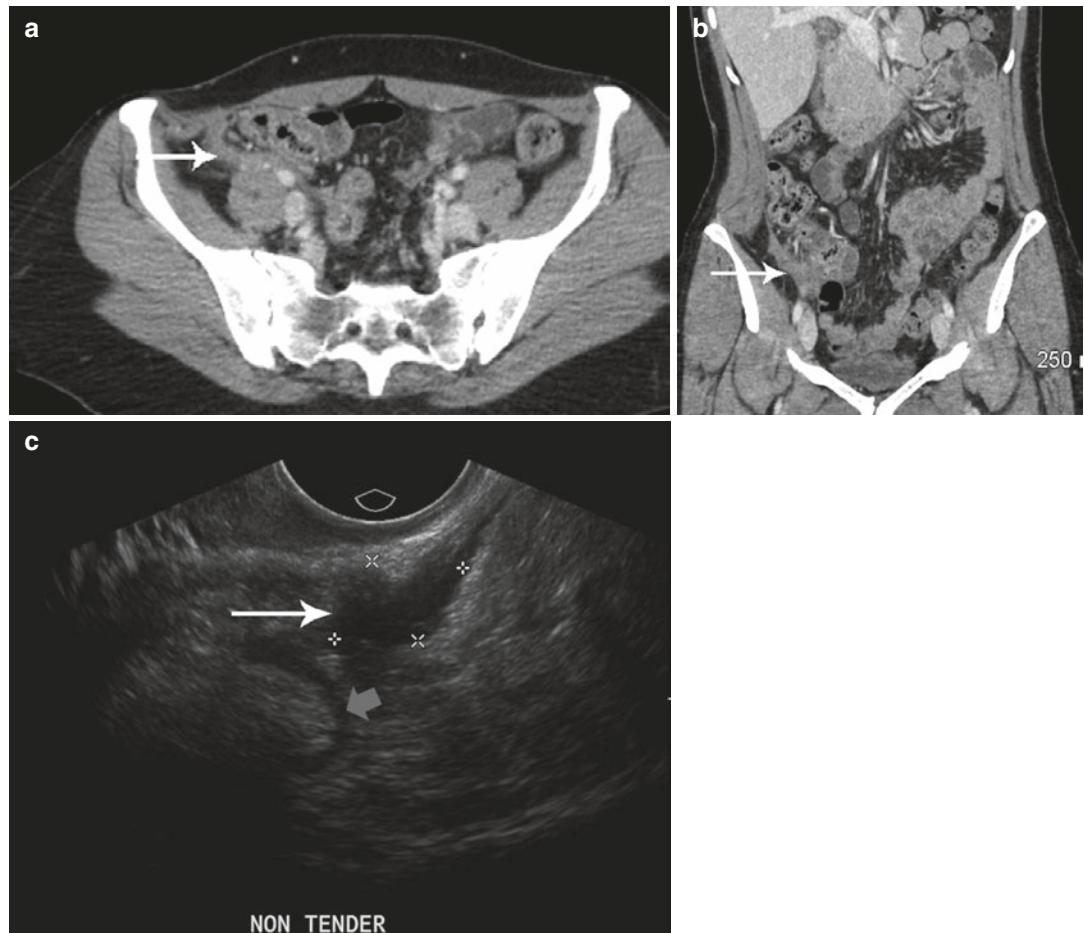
(a) CT of a 32-year-old woman presenting with right lower quadrant pain who was brought to the OR subsequent to a CT diagnosis of acute-on-chronic appendicitis. Irregular-shaped soft tissue was seen in the right lower quadrant next to the external iliac vessels (short gray arrow). These were found to be endometriotic plaques at the OR.
